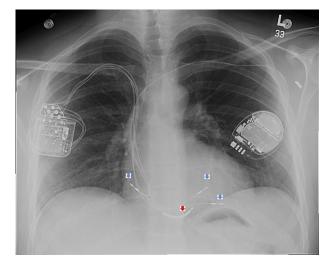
Posteroanterior chest radiograph showing the implantable cardioverter-defibrillator (ICD) on the left upper chest with an ICD lead (red arrow) and the cardiac contractility modulation device on the right upper chest with its leads (blue arrows).
